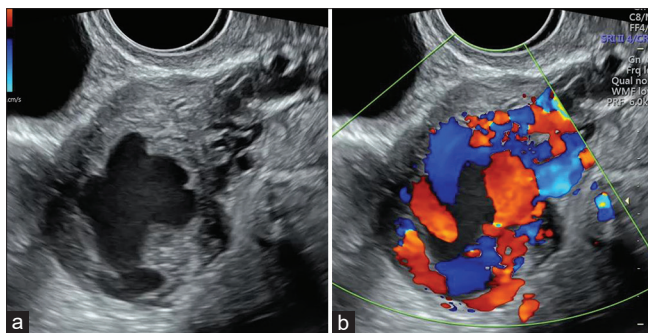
Transvaginal ultrasound (a: B-mode image, b: color Doppler image, 14 days after the surgery). (a) A 30-mm pulsatile mass was found in the right uterine horn. (b) A mosaic-like blood flow signal was observed in the mass
